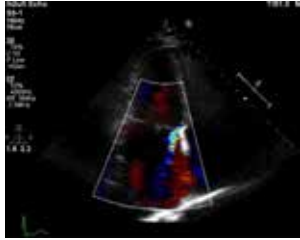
2D transthoracic echocardiogram shows iatrogenic mitral cleft at the basal part of anterior leaflet.
